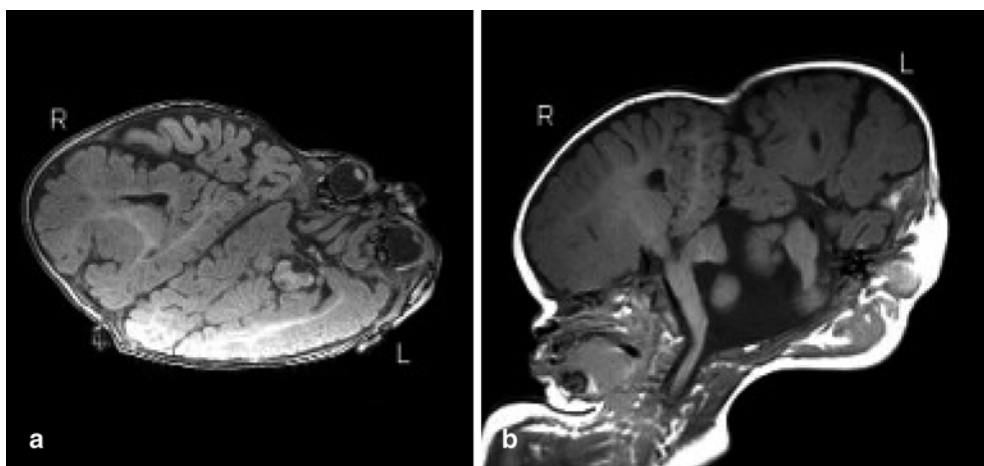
a T1-weighted MR image in oblique plane for right child (*R*) and transverse plane for left child (*L*), showing two separate cerebra divided by an incomplete dura at the fusion site. Due to deformation of the skulls, the brains are slightly deformed. However, no
